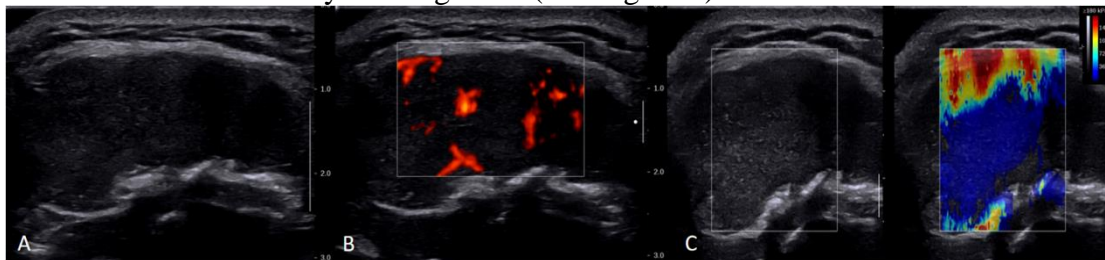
Ultrasound manifestation of right anterior chest wall mass
